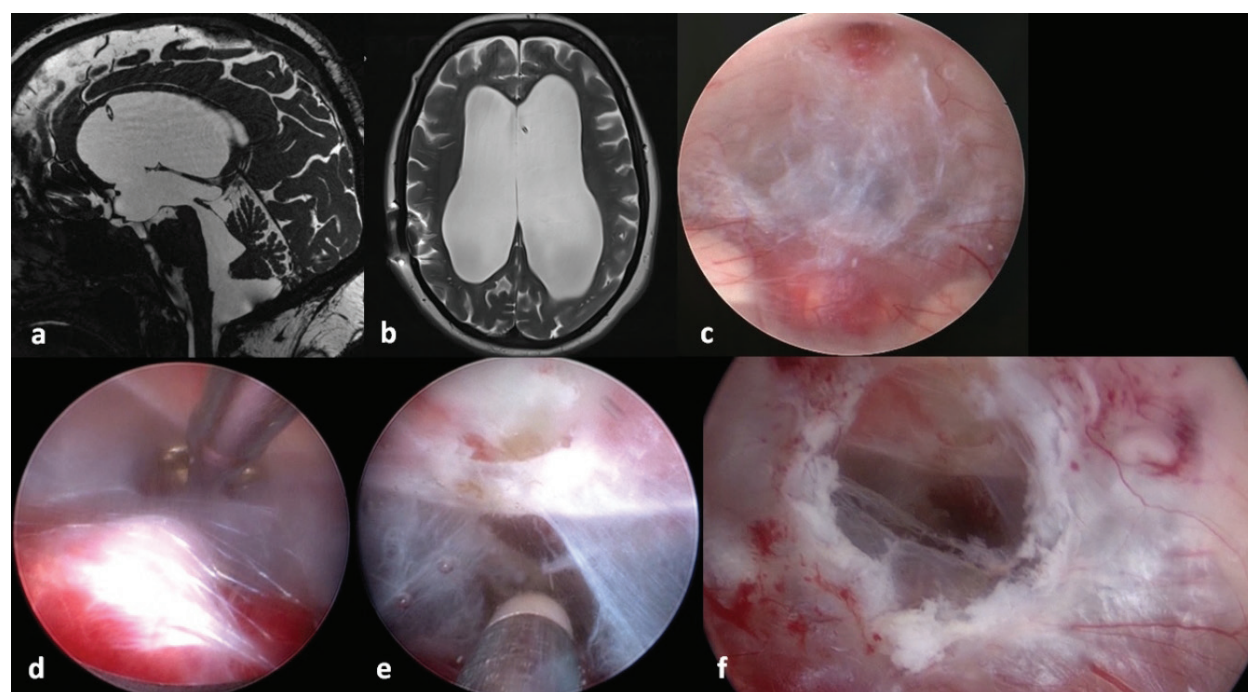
Hydrocephalus with shunt malfunction (a and b) preoperative MRI scan, (c) scarred thick floor of the third ventricle, (d) perforation of adhesions in the prepontine cistern with forceps, (e) with bipolar diathermy, and (f) view on the cisterns through the ventriculostoma.
